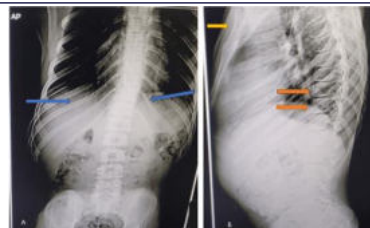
A) X-ray lumbar spine (AP view) showing long slender ribs (blue arrow) on both sides of thorax. B) Radiograph of DL spine (lateral view) showing Platyspondyly (orange arrows) and prominent sternum (yellow arrow).
